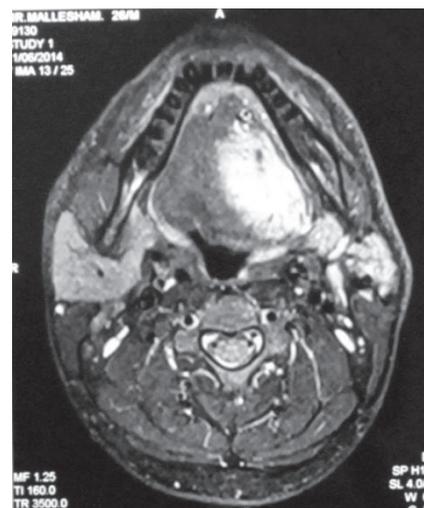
MRI of tongue showing the extent of lesion
